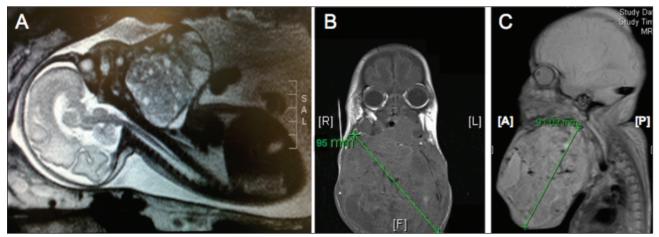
(A) Foetal MRI demonstrating a cervical teratoma obstructing the airway in utero, MRI of neonate post-delivery demonstrating (B) coronal view and (C) sagittal view of the same cervical teratoma in excess of 9cm in diameter.
